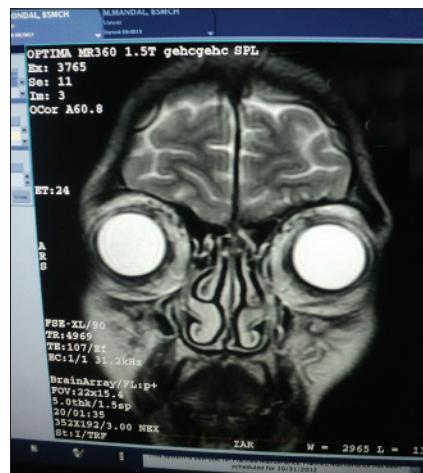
MRI-Coronal & axial view, showing normal cavernous sinus, superior orbital fissure and orbital apex of the patient
